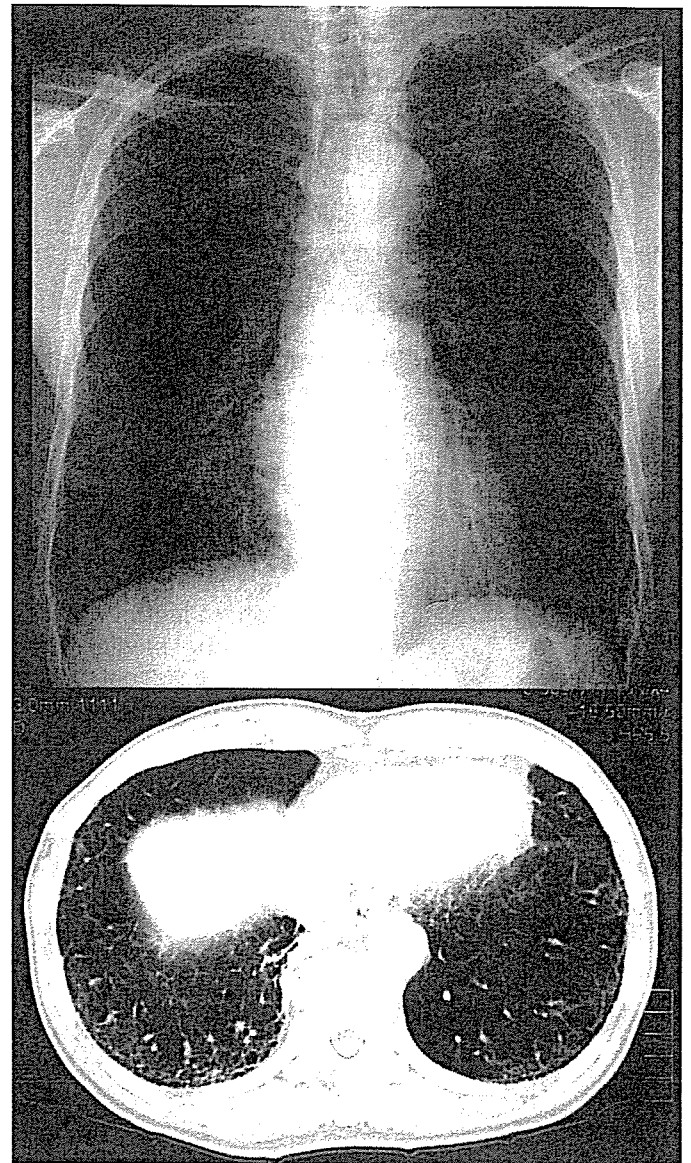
Moderate interstitial shadow. An X-ray film of the chest shows bilateral reticular shadow in the basal area. A CT film of the chest demonstrated bilateral reticular shadow just below the pleura. Interstitial shadow is distributed in 10–30% of the bilateral lower lobes, with this being classified as moderate.
